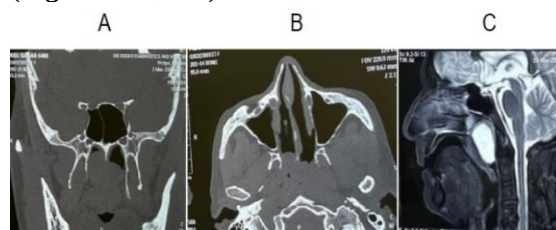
Computed tomography of nose and paranasal sinus (A coronal and B axial view) demonstrating well circumscribed lesion in upper posterior nasopharynx. (C) Magnetic Resonance Imaging Sagittal view demonstrating T2W hyperintense midline lesion in the nasopharynx.
